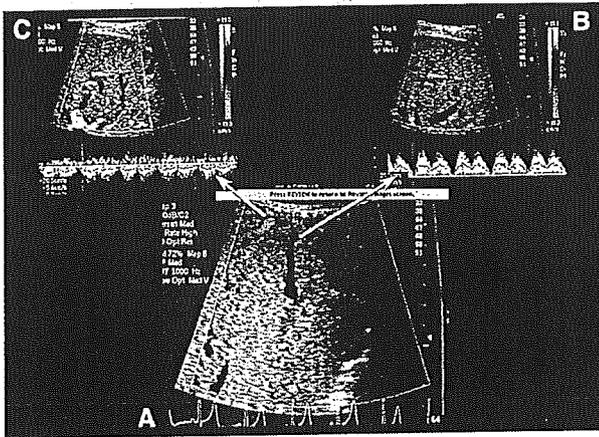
A, Color Doppler US demonstrating intrahepatic venous anastomosis between the MHV tributary (V5) and the RHV. B, Pulsed Doppler US at V5 showing reversed flow toward the anastomosis. C, Pulsed Doppler US at the RHV showing flow away from the anastomosis.
